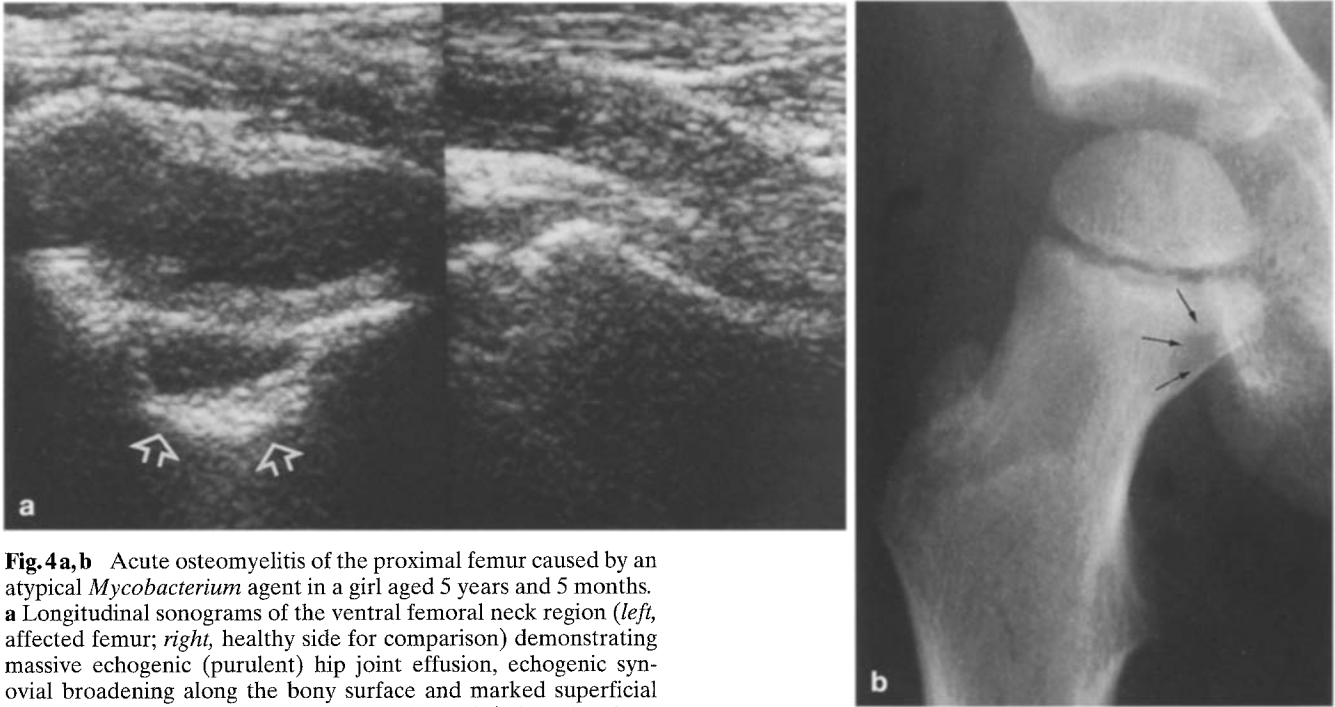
Acute osteomyelitis of the proximal femur caused by an atypical *Mycobacterium* agent in a girl aged 5 years and 5 months. a Longitudinal sonograms of the ventral femoral neck region (*left*, affected femur; *right*, healthy side for comparison) demonstrating massive echogenic (purulent) hip joint effusion, echogenic synovial broadening along the bony surface and marked superficial cortical defect (*open arrows*). b Plain radiograph (taken elsewhere 4 days before admission) showing a distinct localized subcortical lytic area in medial parts of the femoral neck without complete cortical destruction or periosteal reaction (*arrows*)
